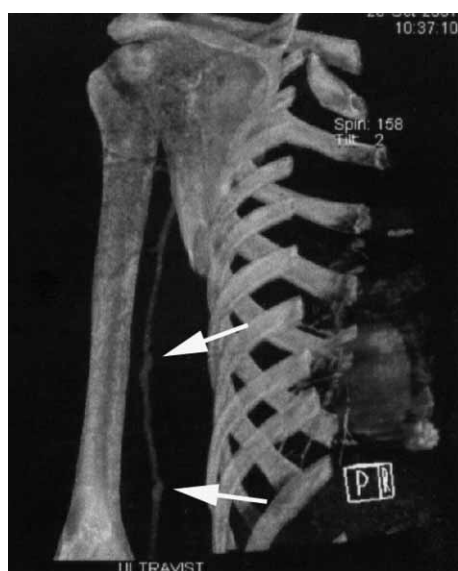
CT Angiography of the left brachial artery five years after injury, P-R projection. Arrows are showing the places of anastomosis between proximal and distal parts of the left brachial artery with reversed interposition saphenous vein graft.
